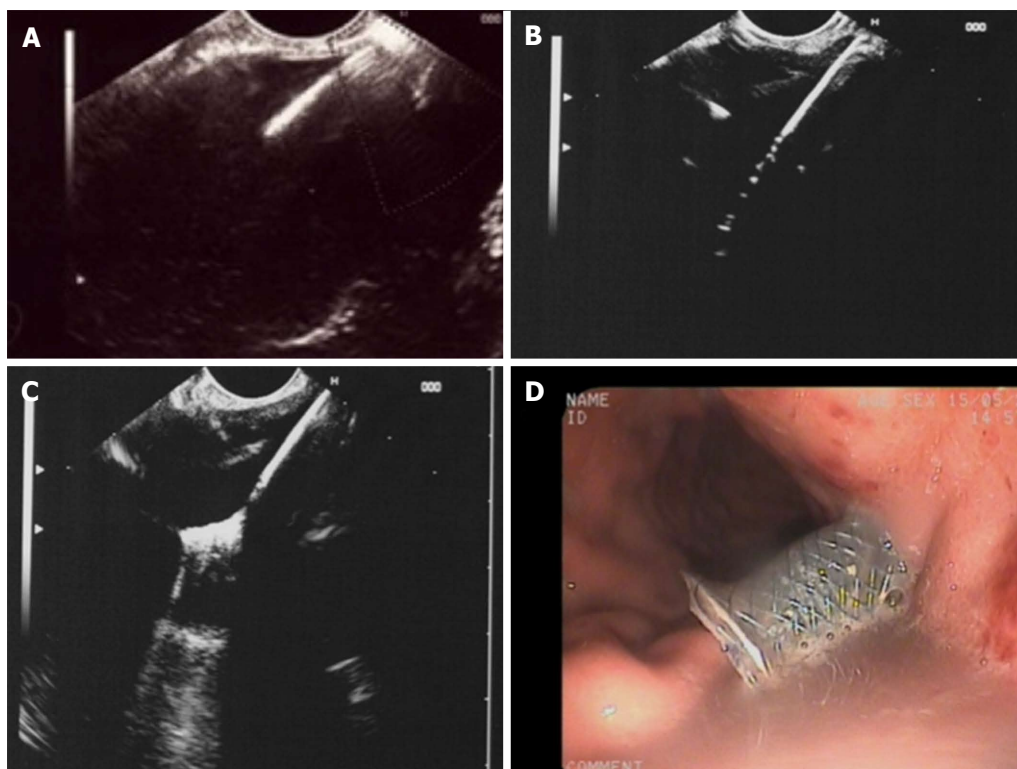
Endoscopic ultrasound-guided transgastric insertion of a fully covered self-expanding metal stent into a walled-off necrosis. A: Transmurals access using the the cystotome; B: Insertion and coiling of the guidewire into the cavity; C: Opening of the distal flange; D: Endoscopic confirmation of correct positioning.
